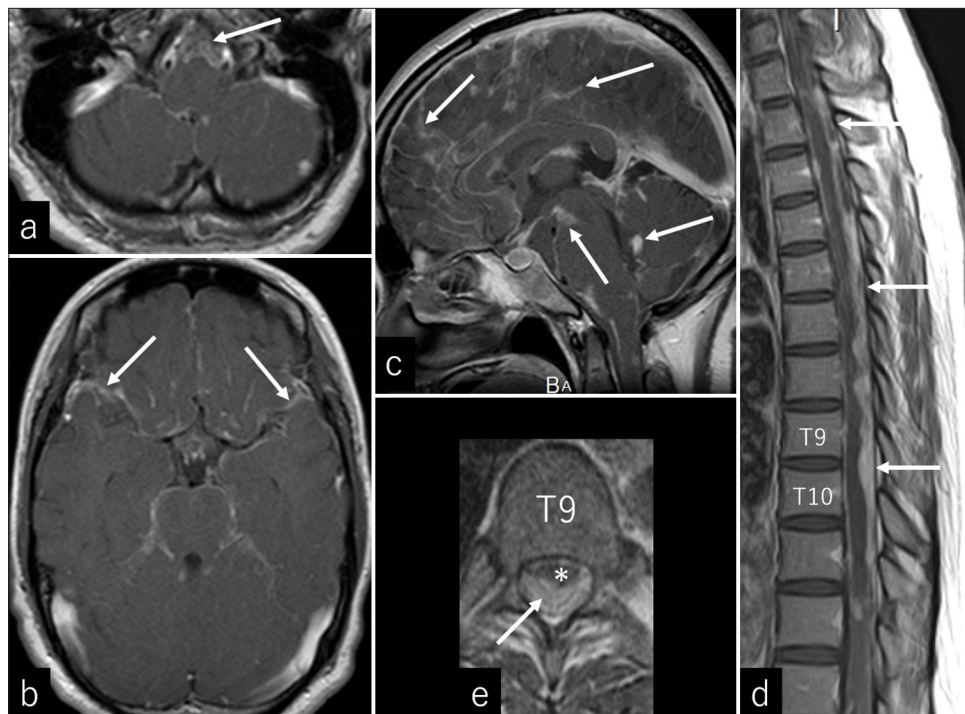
(a-c) Postcontrast (a and b) and (c) sagittal cerebral magnetic resonance images performed 2 months later, at the levels of (a) the medulla oblongata and (b) upper midbrain, showing diffuse leptomeningeal enhancements along the cerebral cisterns, sulci, and fourth ventricle (arrows). (d and e) Postcontrast (d) sagittal and (e) axial magnetic resonance image of the spine showing diffuse leptomeningeal enhancements along the spinal cord, with massive tumors considerably compressing the dorsal cord (arrows). Asterisk: Spinal cord.
